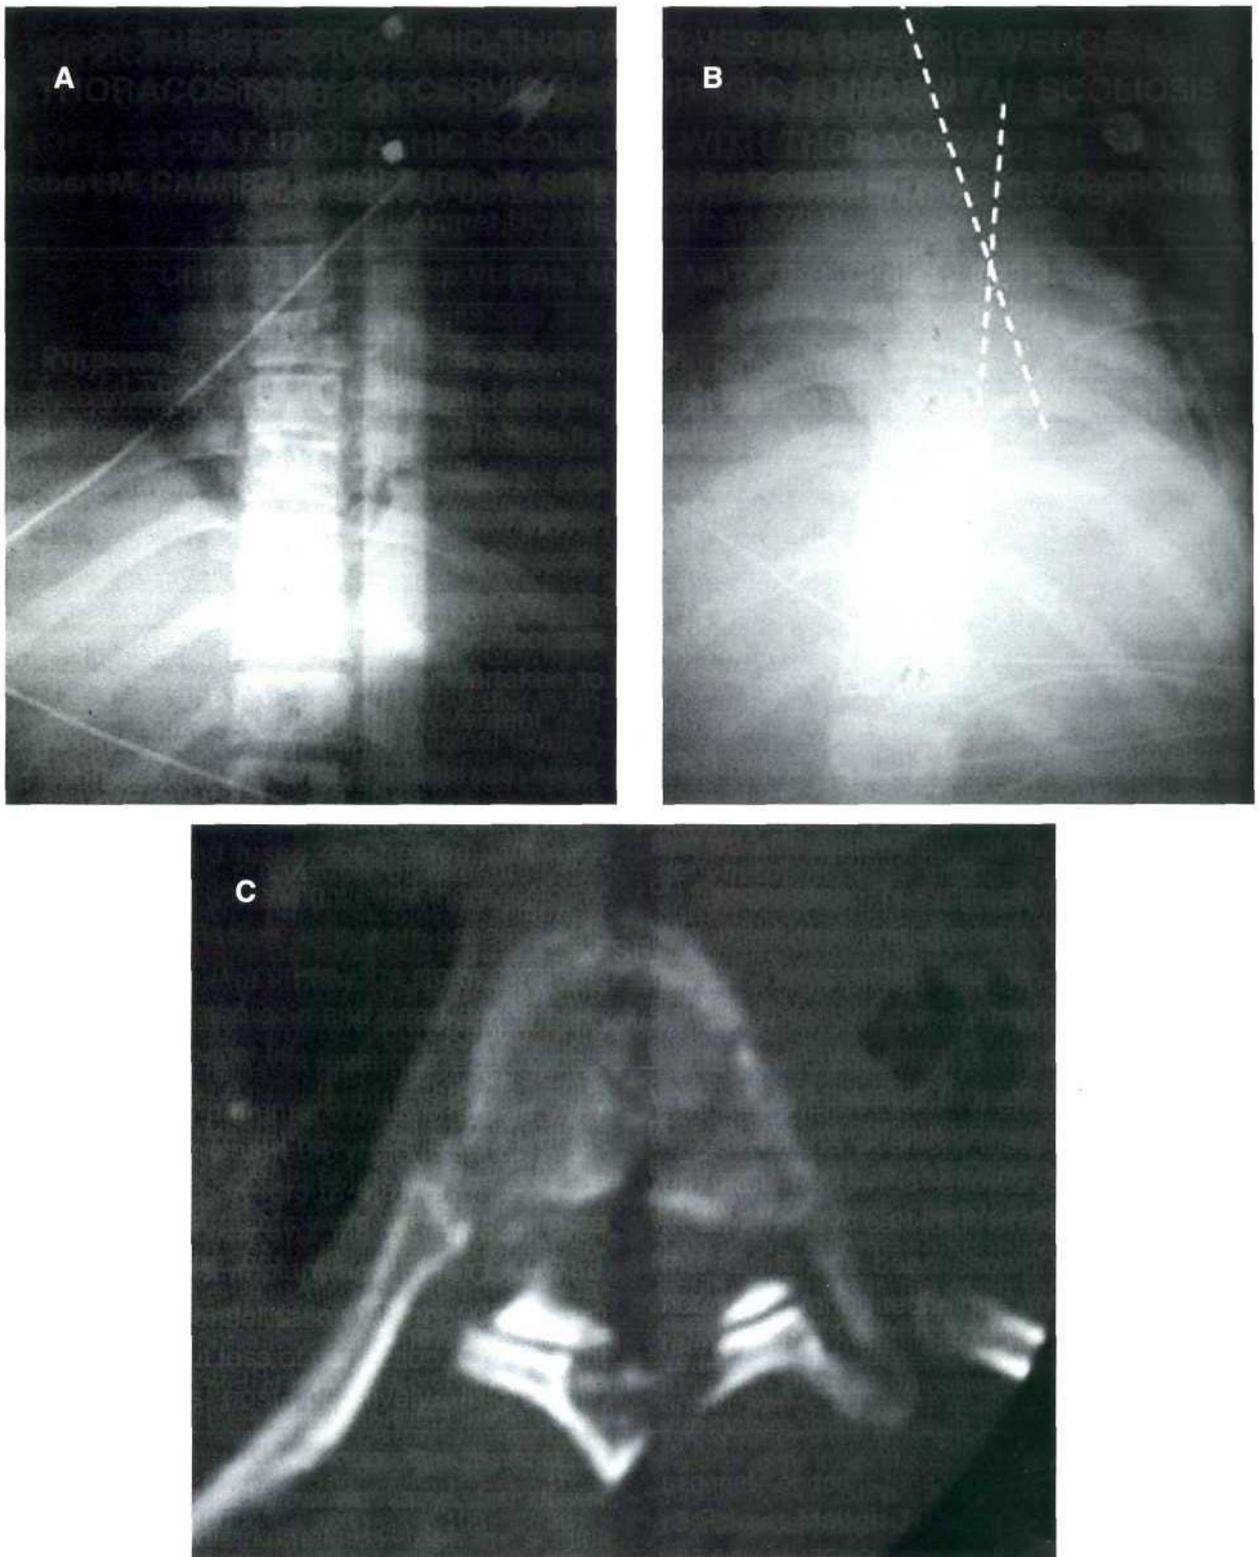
Initial supine chest radiograph of a 27-year-old woman who had blunt chest trauma in a motor vehicle accident; she was neurologically intact (A). Control radiography and CT demonstrates right lateral displacement of the T7 vertebral body with acute angulation of the pedicle lines at the T7-8 level indicating a T7-8 fracture (B and C).
